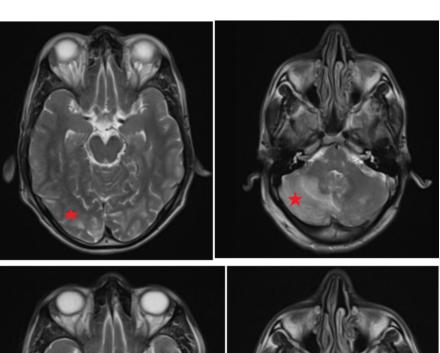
Hyperintensity in T2 Flair sequence on brain MRI.
